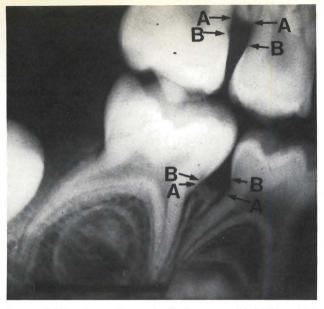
Bitewing radiograph of a five-year-old child in which the reference points utilized for the measurements are indicated. A = alveolar bone, B = cementoenamel junction.
